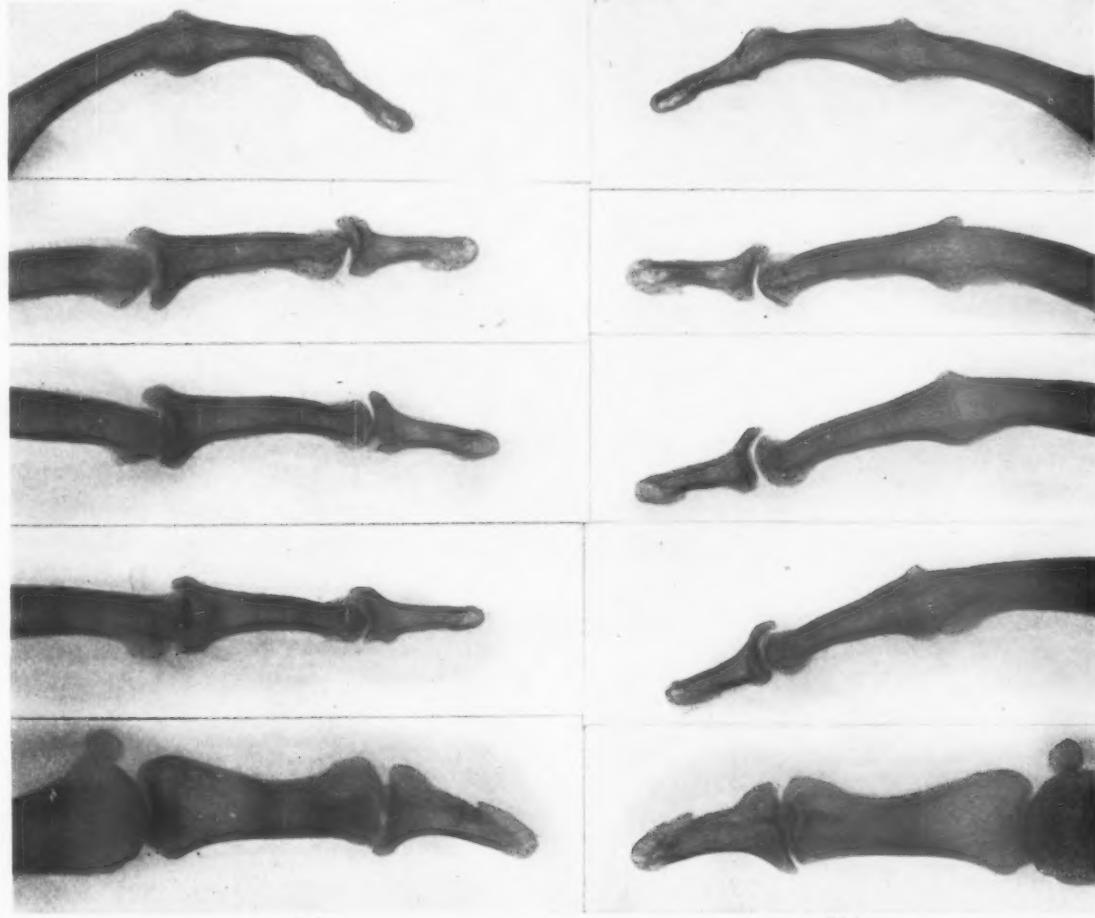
Case 3, lateral radiographs of the fingers 17 years after onset showing complete fusion of all the joints in both little fingers and in the proximal joints of the other three fingers of the right hand. The proximal joints of the first three fingers of the left hand show marked antero-posterior enlargement of the proximal ends of the middle phalanges. Spurs are seen on the posterior surface of the distal joints of the first three fingers of each hand similar to those seen in Heberden's nodes.
